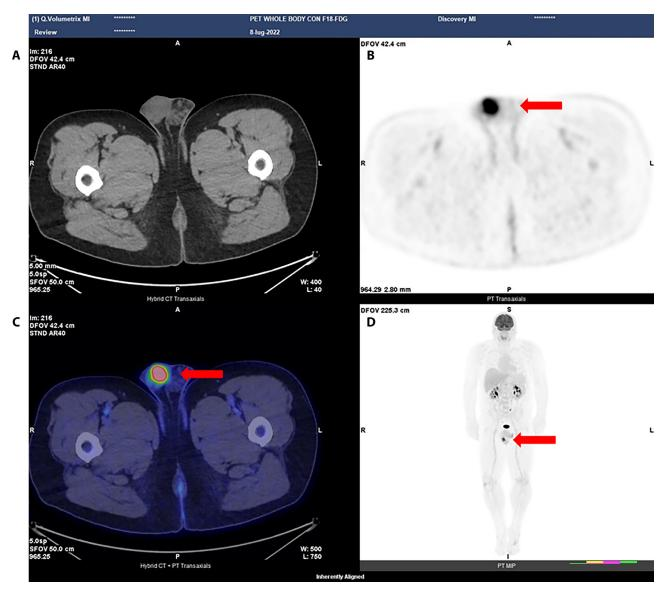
(A) [18F]F-FDG PET/CT transaxial images with low-dose CT. (B) PET. (C) Image fused PET/CT. (D) Maximum intensity projection (MIP). The red arrows in images B, C and D, shows a focal uptake (SUVmax 10) in the right testis.
